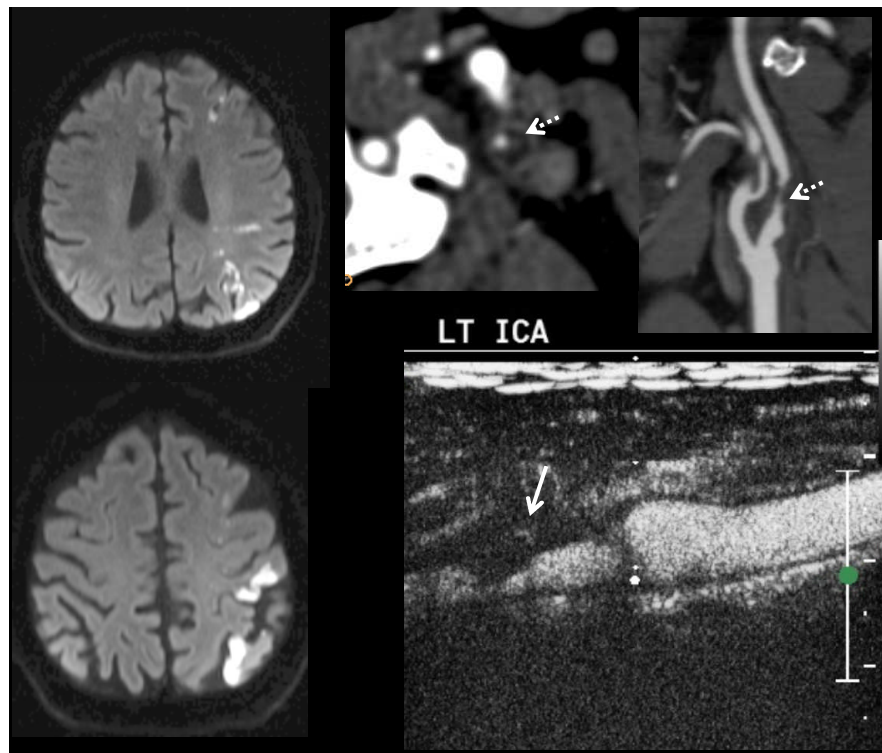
M/ 71 yrs with left MCA stroke. Left ICA 80% stenosis. On CEUS, moving microbubbles are seen on the shoulder of the plaque (black arrows). On MRI plaque imaging, it appears isointense on PD, hypointense on T2WI a with small hyperintense component and hyperintense on T1WI and TOF s/o fibro-fatty plaque with a small hemorrhagic component. Surface ulceration is present.
